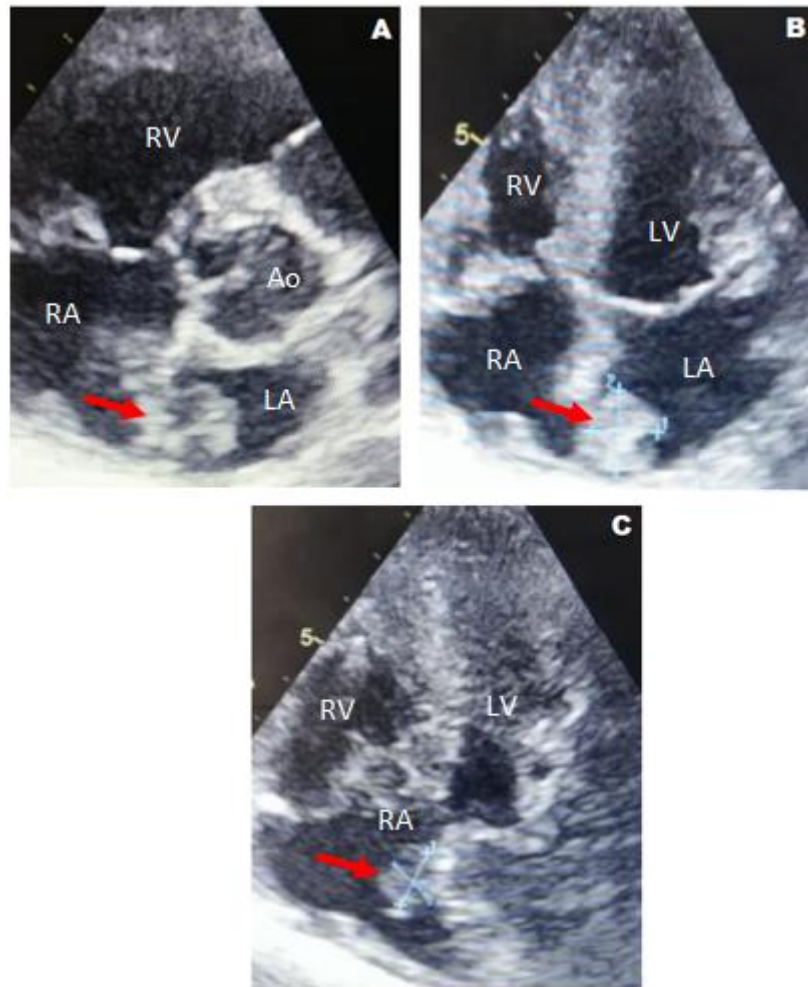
Transthoracic echocardiography (A) Basal parasternal short axis view (B) Apical 4 chamber view (C) Right ventricular apical view : showing two formations on both sides of the surgical atrial septal defect closing patch.
